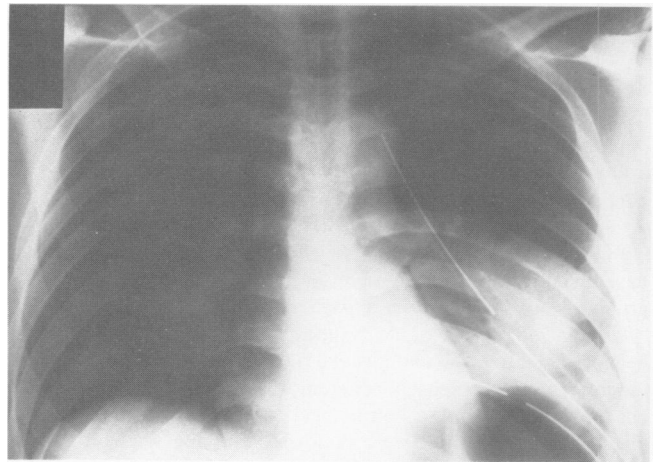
Chest roentgenogram showing elevation of the left diaphragm and the density in the left lower lung field.
